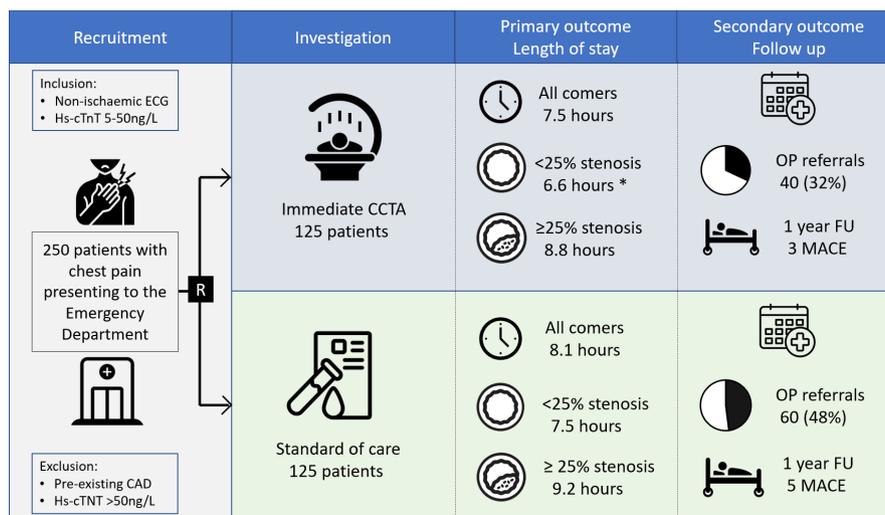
Trial overview. CAD, coronary artery disease; CCTA, coronary CT angiography; FU, follow-up; hs-cTnT, high-sensitivity cardiac troponin T; MACE, major adverse cardiac event; OP, outpatient.
